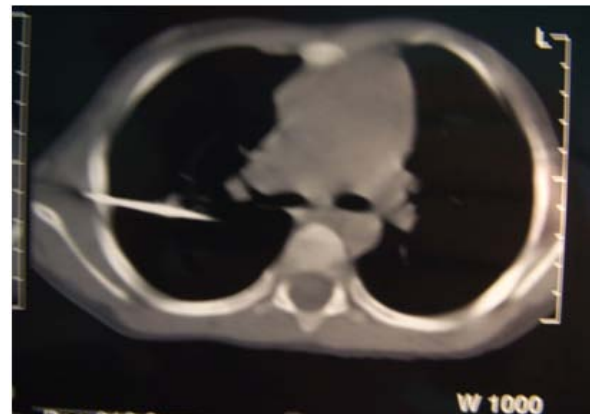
CT shows pin extending from under the scapula to the thoracic cavity in the second patient.
